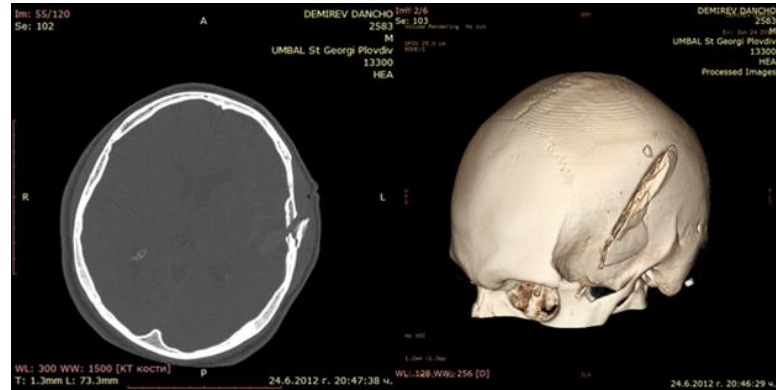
CT image of opened penetrating head injury
